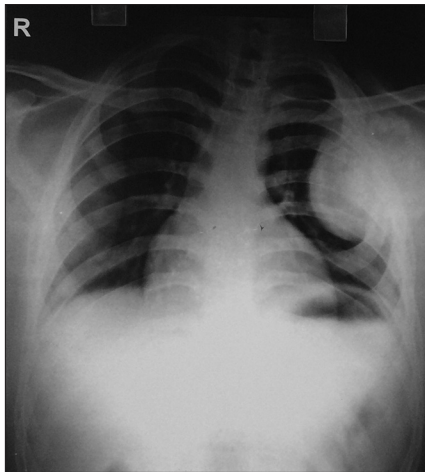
Chest X-ray showing a homogenous opacity in left lung field suggestive of a nonparenchymal lesion
